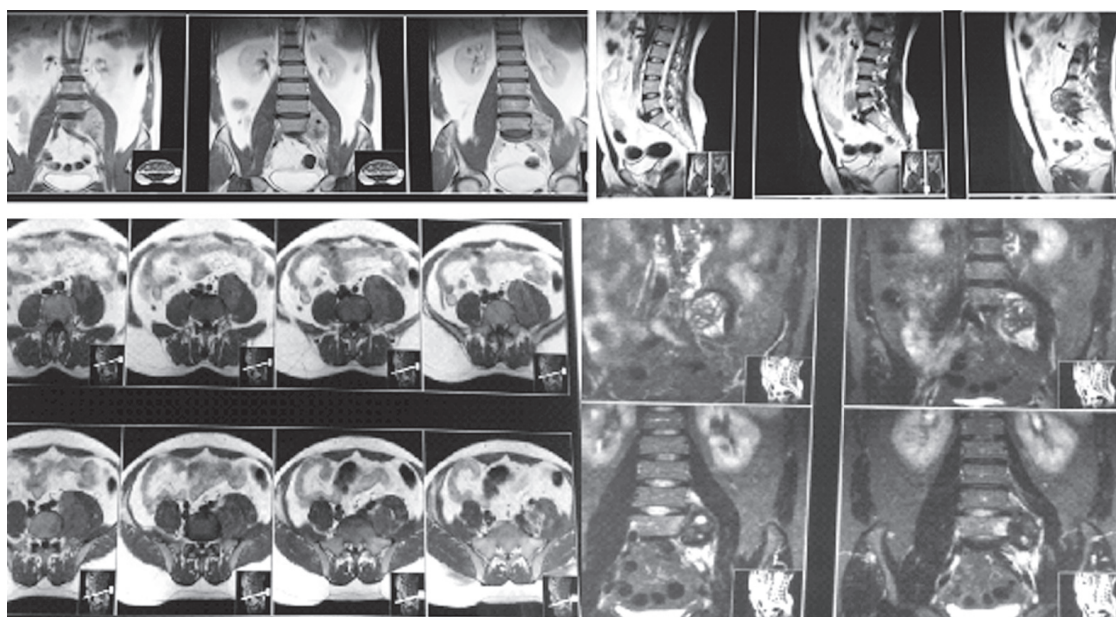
MRI on sagittal, axial, coronal showed a hyperintense lesion of the lumbar spine on T1 weighted images on the posterior aspect of the L3-L4 disc. The lesion is hypointense on T2 weighted images. It showed contrast uptake with gadolinium injection.
